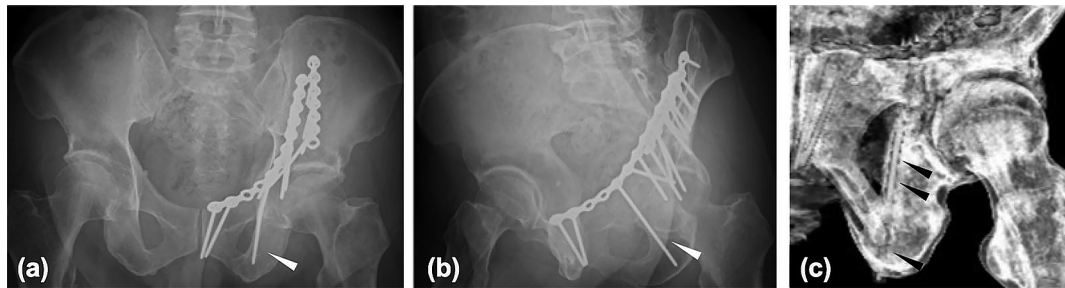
X-ray of the infra-acetabular screw. (a) AP view, (b) obturator-oblique view and (c) 3D-CT of the postoperative X-ray of the infra-acetabular screw (IAS) used in the case of an acetabular fracture. Arrowheads: IAS
